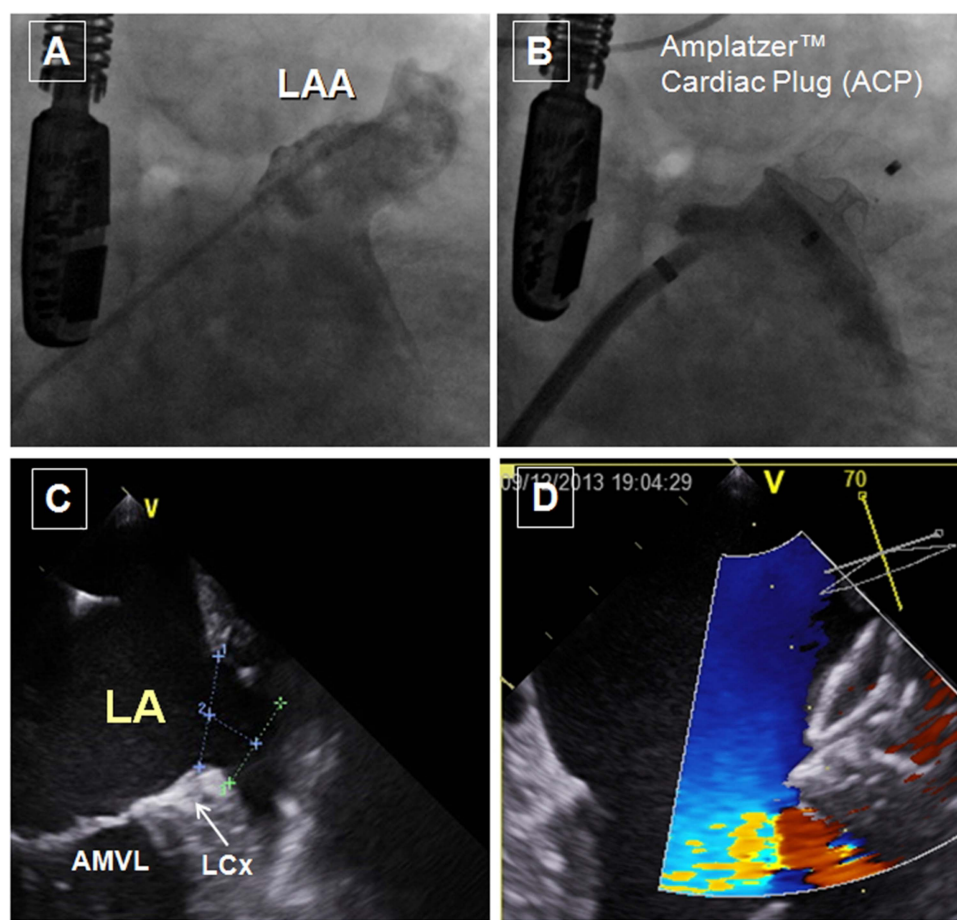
(A) Angiographic imaging of the left atrial appendage (LAA). (B) Position of the Amplatzer Cardiac Plug (ACP) device after implantation in the LAA and angiographic control to assess the success of occlusion immediately post-procedure. (C) 2D multiplanar transoesophageal echocardiography assessment of the ostial dimension of the LAA to determine the size of the device required. The green line represents the dimension taken for the landing zone of the ACP device. (D) Colour Doppler echocardiography post-implantation demonstrating lack of flow. AMVL, anterior mitral valve leaflet; LA, left atrium; LCx, left circumflex artery.
